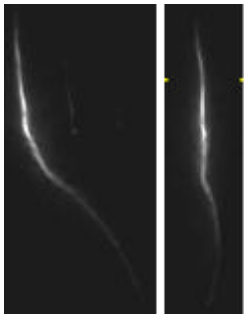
Coronal and sagittal views of an intravascular MRI probe and its 3D reconstructed wire-frame model.
